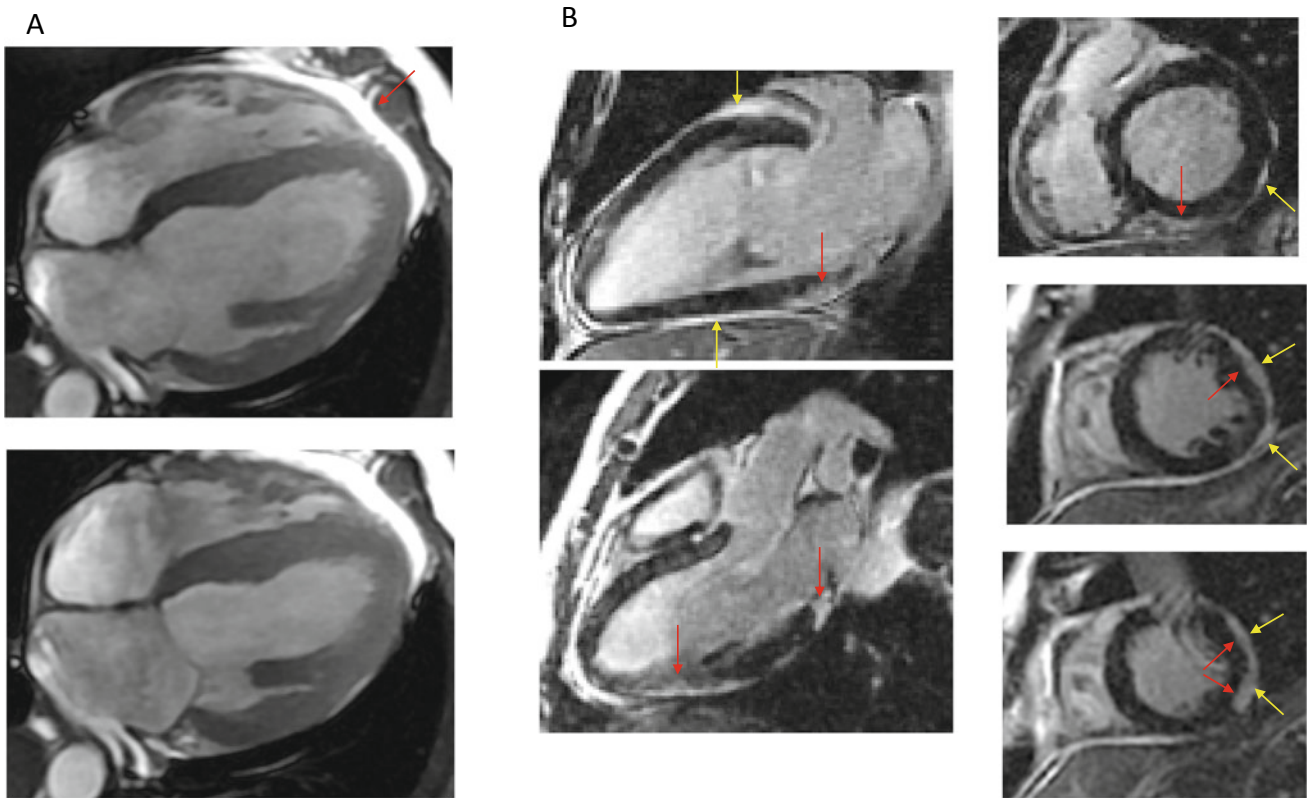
Cardiac MRI of a different patient with COVID-19 showing myopericarditis. A, Still frames from cine-CMR in diastole (top) and systole (bottom) demonstrated moderately reduced global left ventricular systolic function (LV ejection fraction 37%), and pericardial effusion (red arrow). B, Late gadolinium enhancement CMR
